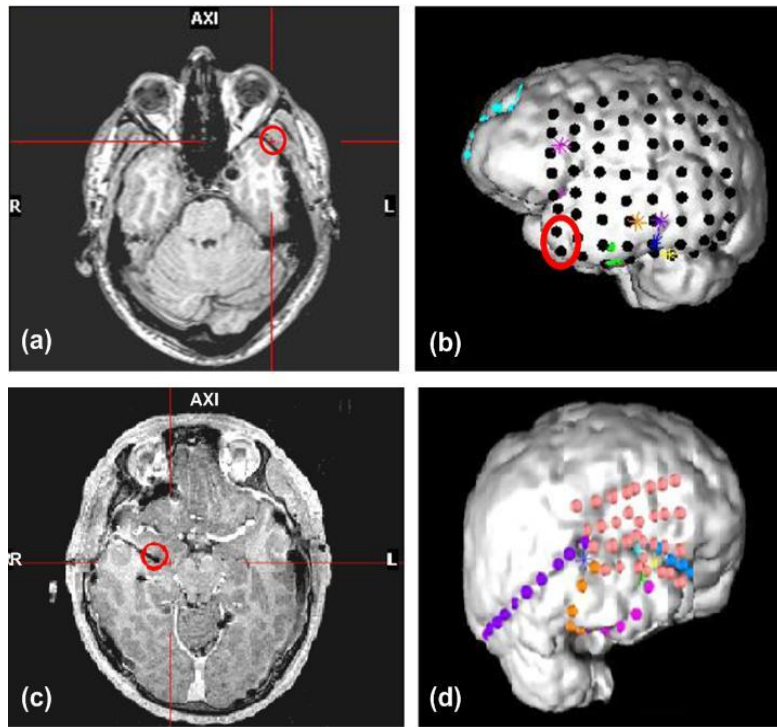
The electrode implementation: (a)-(b) MRI and 3D reconstruction of the first patient, and (c)-(d) MRI and 3D reconstruction of the second patient.
